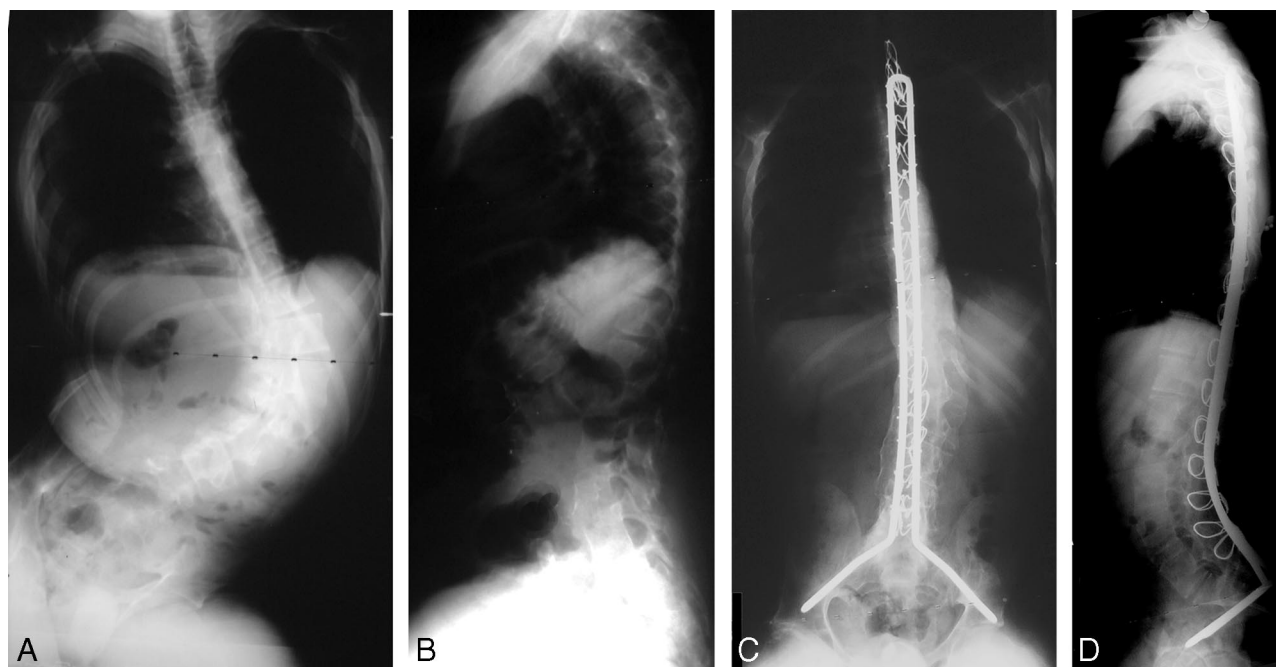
The preoperative radiograph shows a 95° thoracolumbar scoliosis with severe pelvic obliquity (A) and 80° of kyphosis (B). Two years after surgical correction excellent curve correction with a full fusion maintains good alignment (C) and good sagittal plane correction (D).
